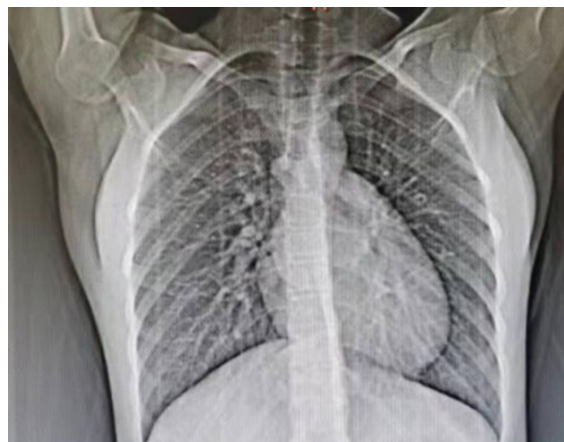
Front view of chest CT for the patient on Dec 9th.
